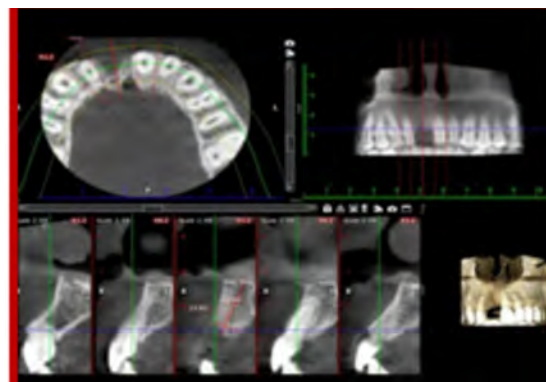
Radiographic evaluation - (b) CBCT scan
